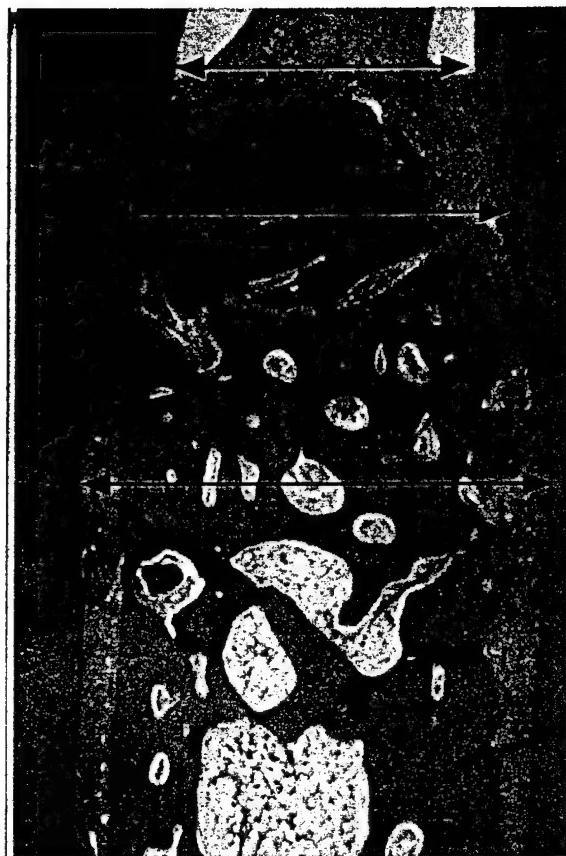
Crestal and Apical QHA Fields. Along a superimposed bisecting line, QHA was performed on 3 fields of bone in the crestal and subjacent apical 2 mm regions. Each field has an area of 0.136 mm^2 ($0.37 \text{ mm} \times 0.37 \text{ mm}$). (HE x 22).
